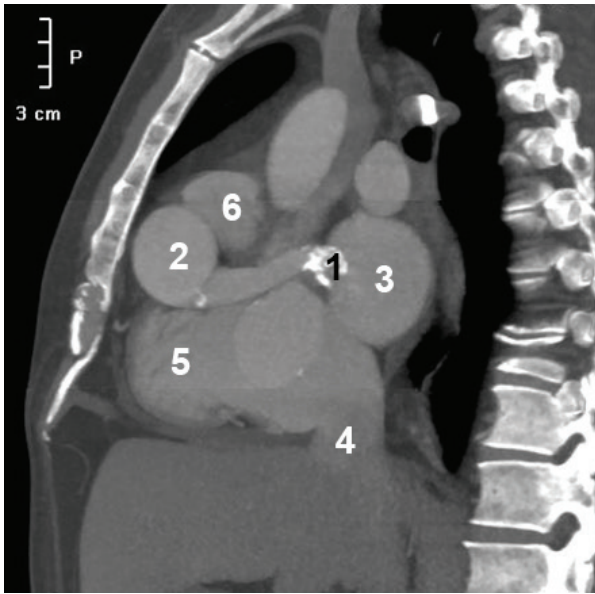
CT angiogram oblique sagittal image. 1, distal end of tunnel; 2, proximal end of tunnel; 3, left atrium; 4, inferior vena cava; 5, right ventricle; 6, pulmonary trunk; 7, descending aorta. There is a small dense calcification at the origin of the tunnel and dense mural calcifications at the distal end of the tunnel. The tunnel is long, tortuous and dilated.
